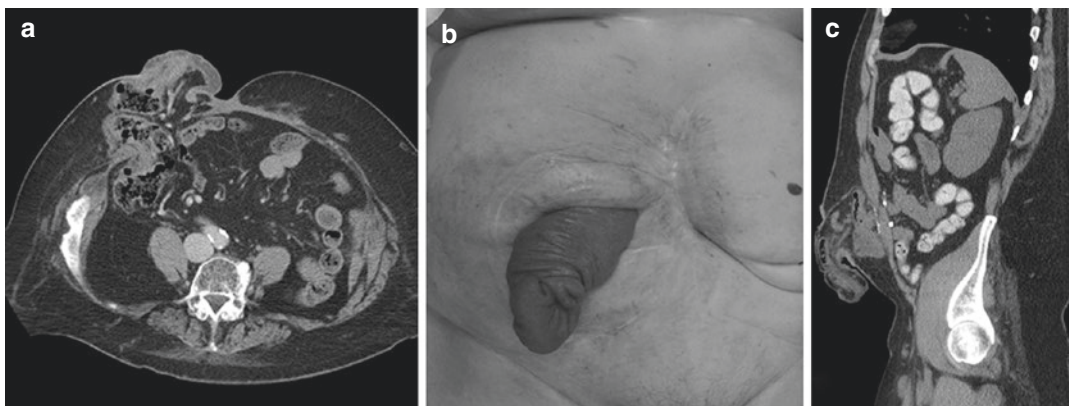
Recurrent parastomal hernia with prolapse seen (a) radiographically on axial CT scan and (b) on physical examination (c) radiographically on sagittal CT scan
